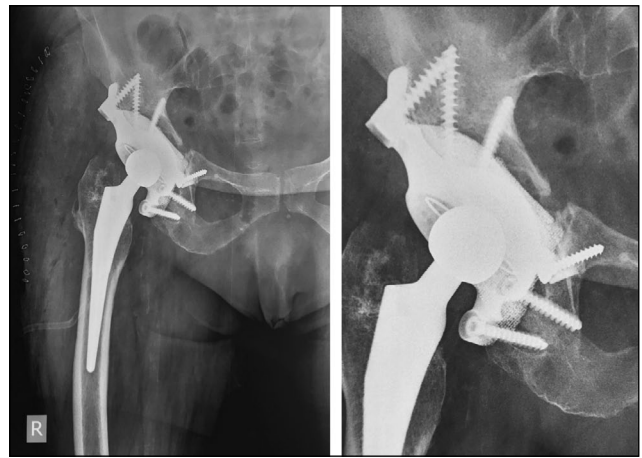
Postoperative control X-ray.
